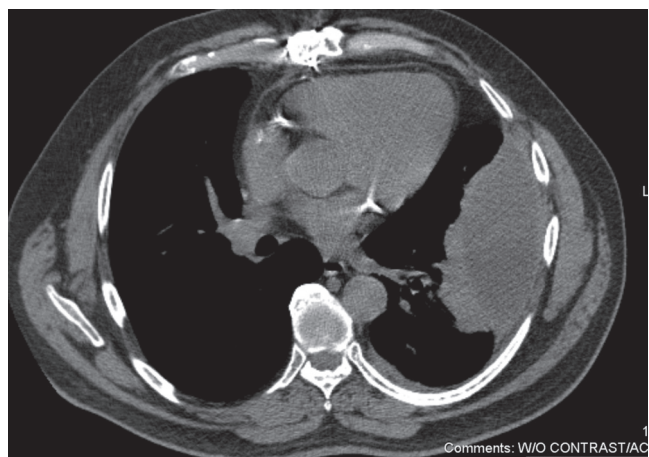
■ CT scan of a patient who required VATS decortication. The lenticular, loculated appearance suggests intraoperative drainage is required.
